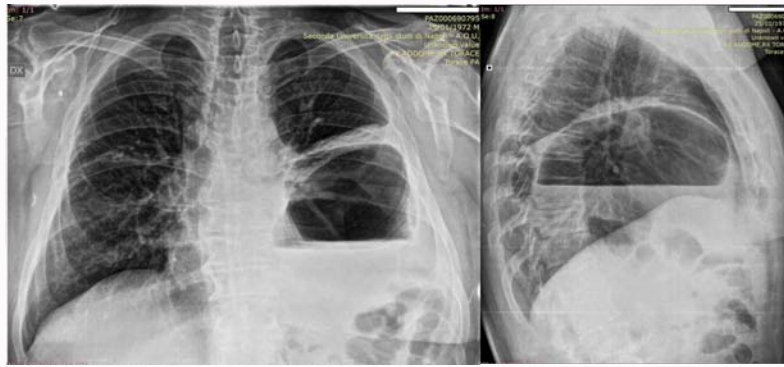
Chest X-Ray in PA and lateral view, showing air-fluid levels by the herniated stomach in the left pleural cavity.
